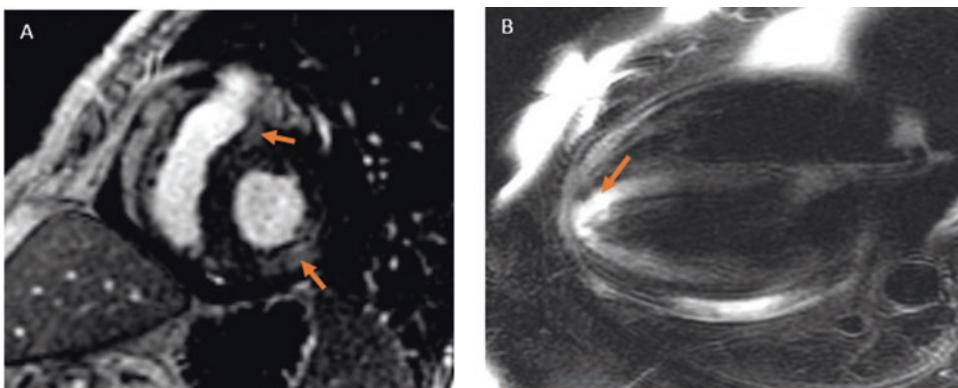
Cardiac MRI findings showing myocarditis. (a) Image showing late gadolinium enhancement within the myocardium. (b) Increased T2 signal showing edema
